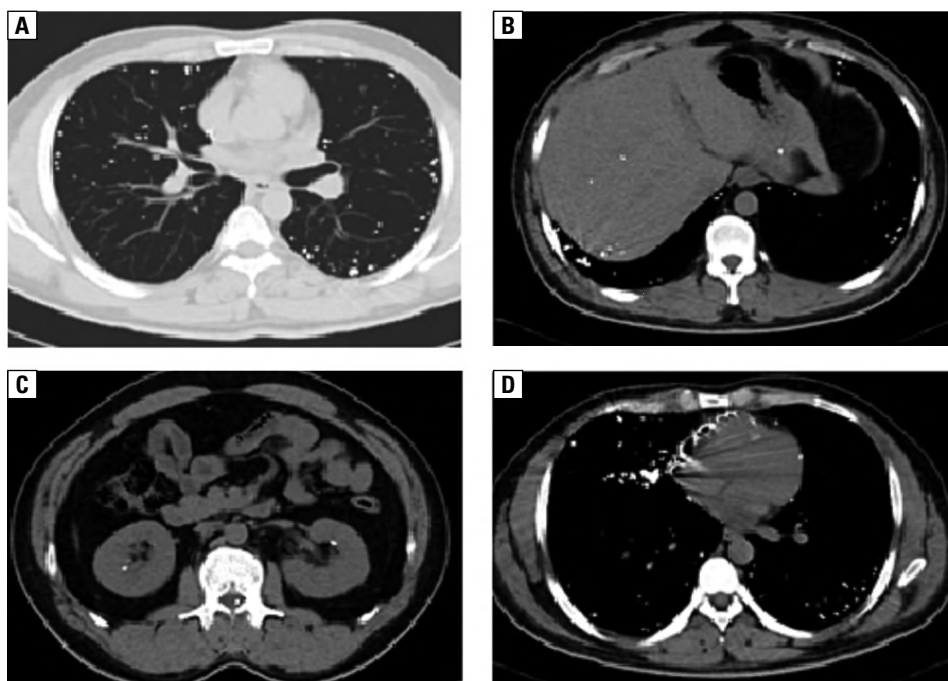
CT chest showed multiple diffusely distributed metallic densities in bilateral lung, pericardium, liver, kidneys and multiple vertebral bodies and foramina
